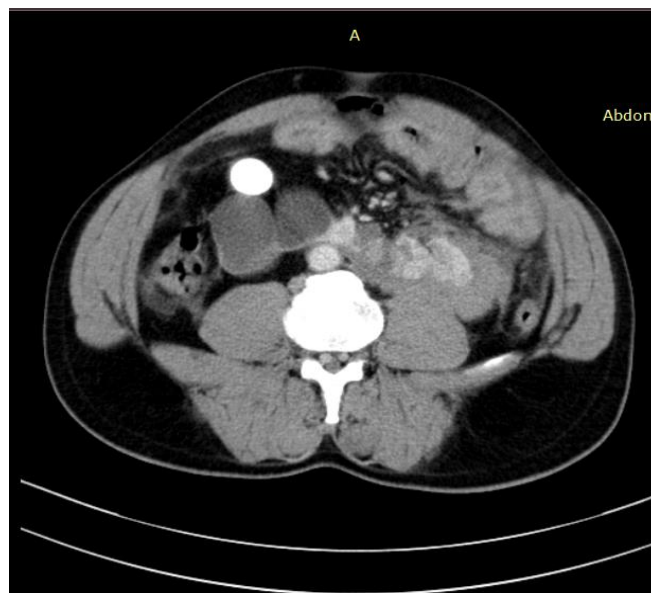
Axial CT post contrast image at the upper isthmic level showing laceration of the left half of isthmus with peri nephric hematoma. The right half shows dilatation of pelvicalyceal system of the lower moiety and a calculus obstructing the dilated right upper ureter.
